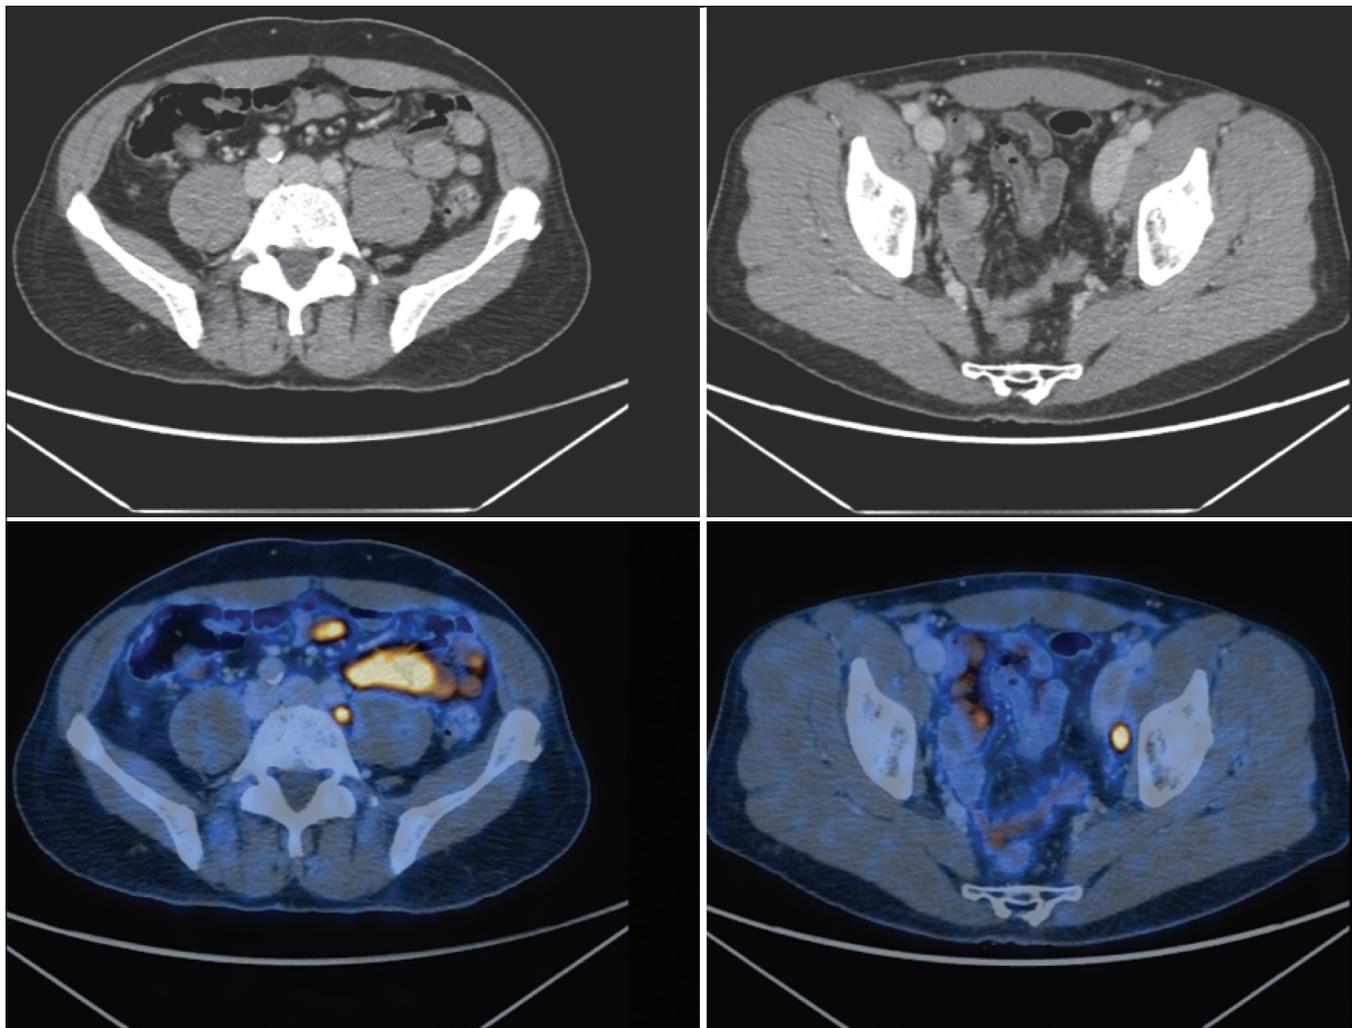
⁶⁸Ga-PSMA PET/CT showing high uptake of the radiopharmaceutical in pelvic, obturator, and left external iliac lymph nodes, which were confirmed as being metastatic.
